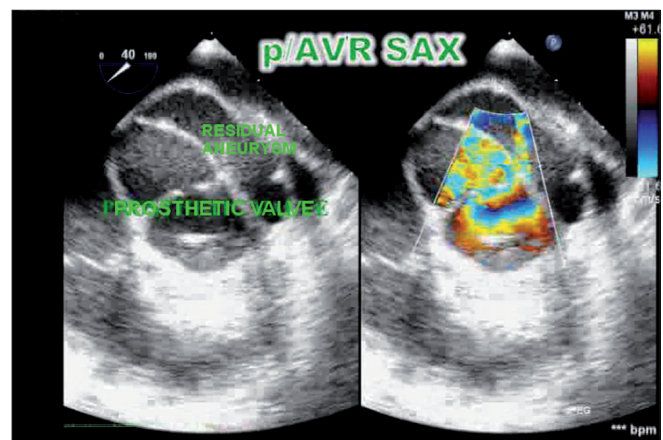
Post-aortic valve replacement mid-esophageal aortic long axis color Doppler view showing prosthetic valve with residual ruptured aneurysm into left ventricular cavity. LV: left ventricle
